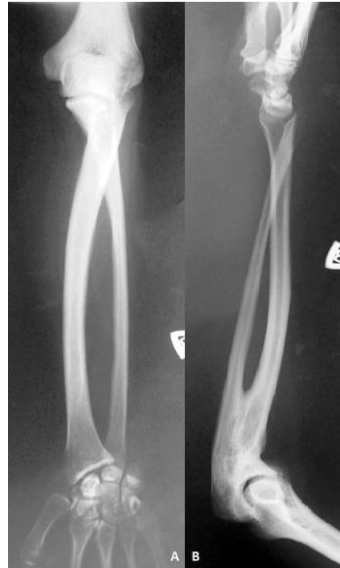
X-ray image of the left forearm in postero-anterior (a) and lateral (b) projection
